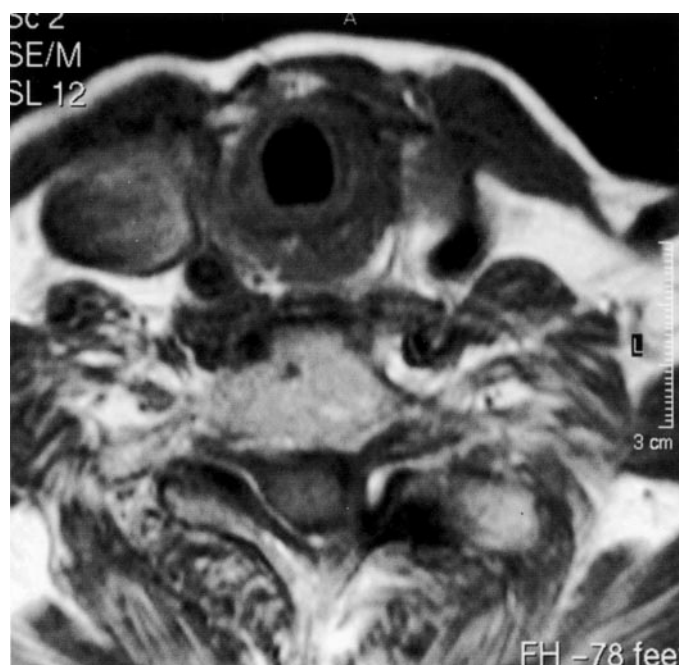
Patient 2. MRI of the neck before rhTSH.
